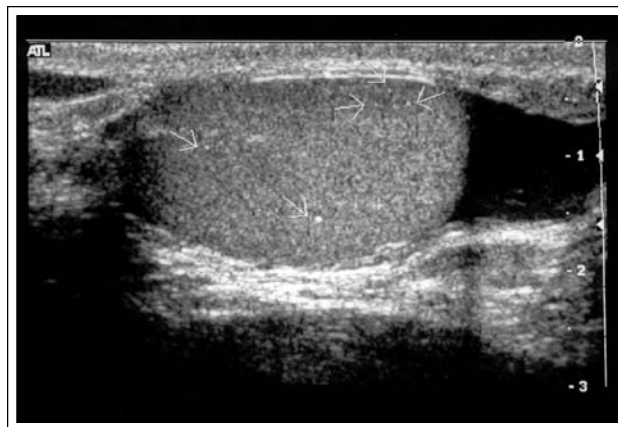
Sagittal ultrasound view of the contralateral testis demonstrating microlithiasis.
